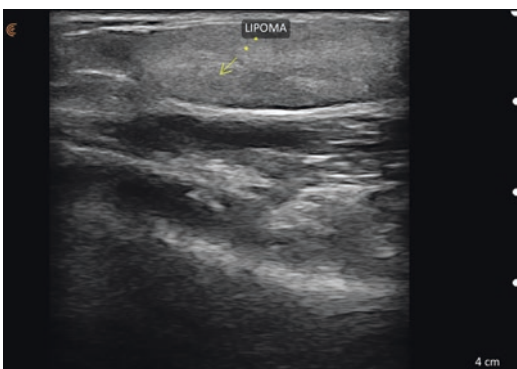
Grayscale ultrasound image of lateral arm. Longitudinal orientation of the transducer over the lateral distal arm shows the well demarcated, homogeneous hyperechoic nature of the lipoma
